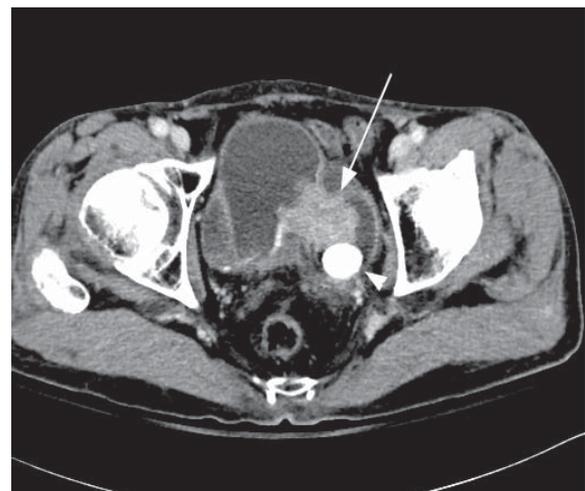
Contrast-enhanced computed tomography demonstrating an enhanced mass involving the vesical diverticulum (arrow) with total occlusion of the diverticular neck. A radiopaque lesion is found in the interior of the diverticulum (arrow head).
